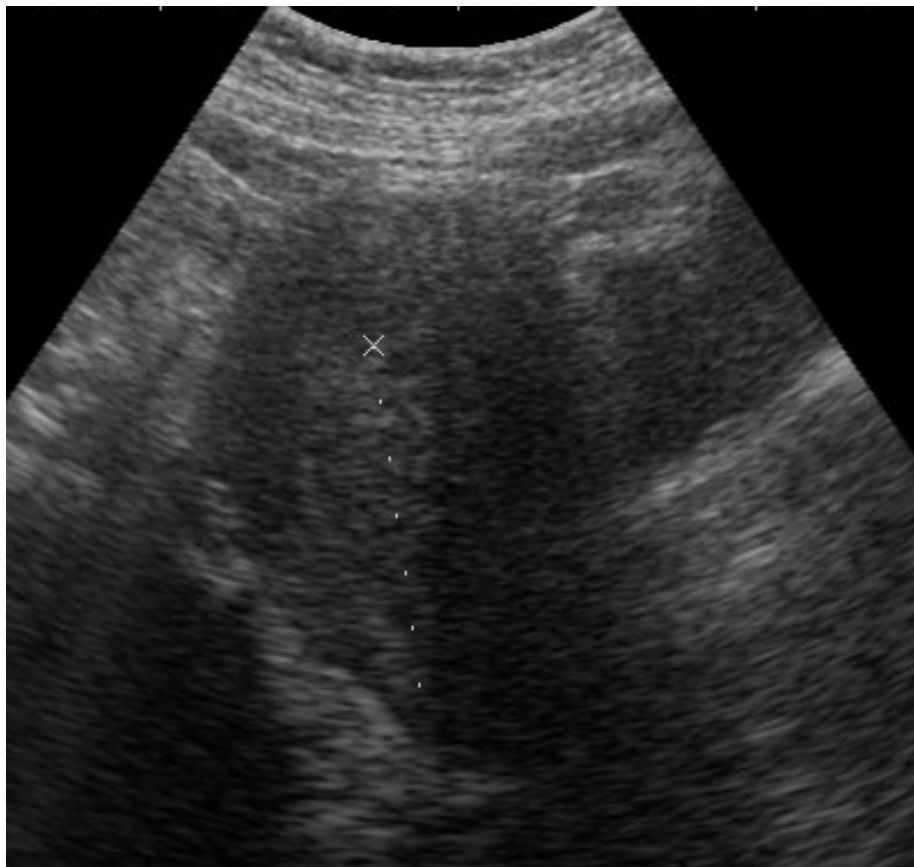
Sagittal transvaginal sonogram demonstrating an ill-defined mass within the posterior myometrium (between cursors).
